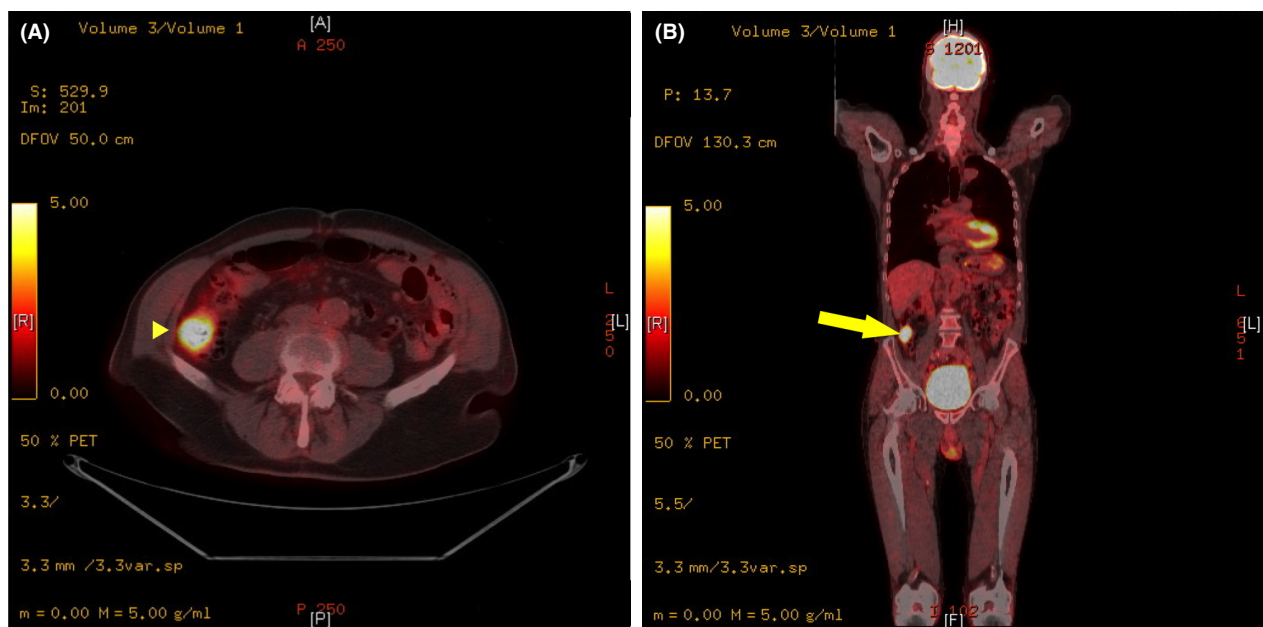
Yellow arrow: Mass in the ascending colon, diameter of 3.5 cm, with significantly increased glucose metabolism of SUVmax 8.9.
